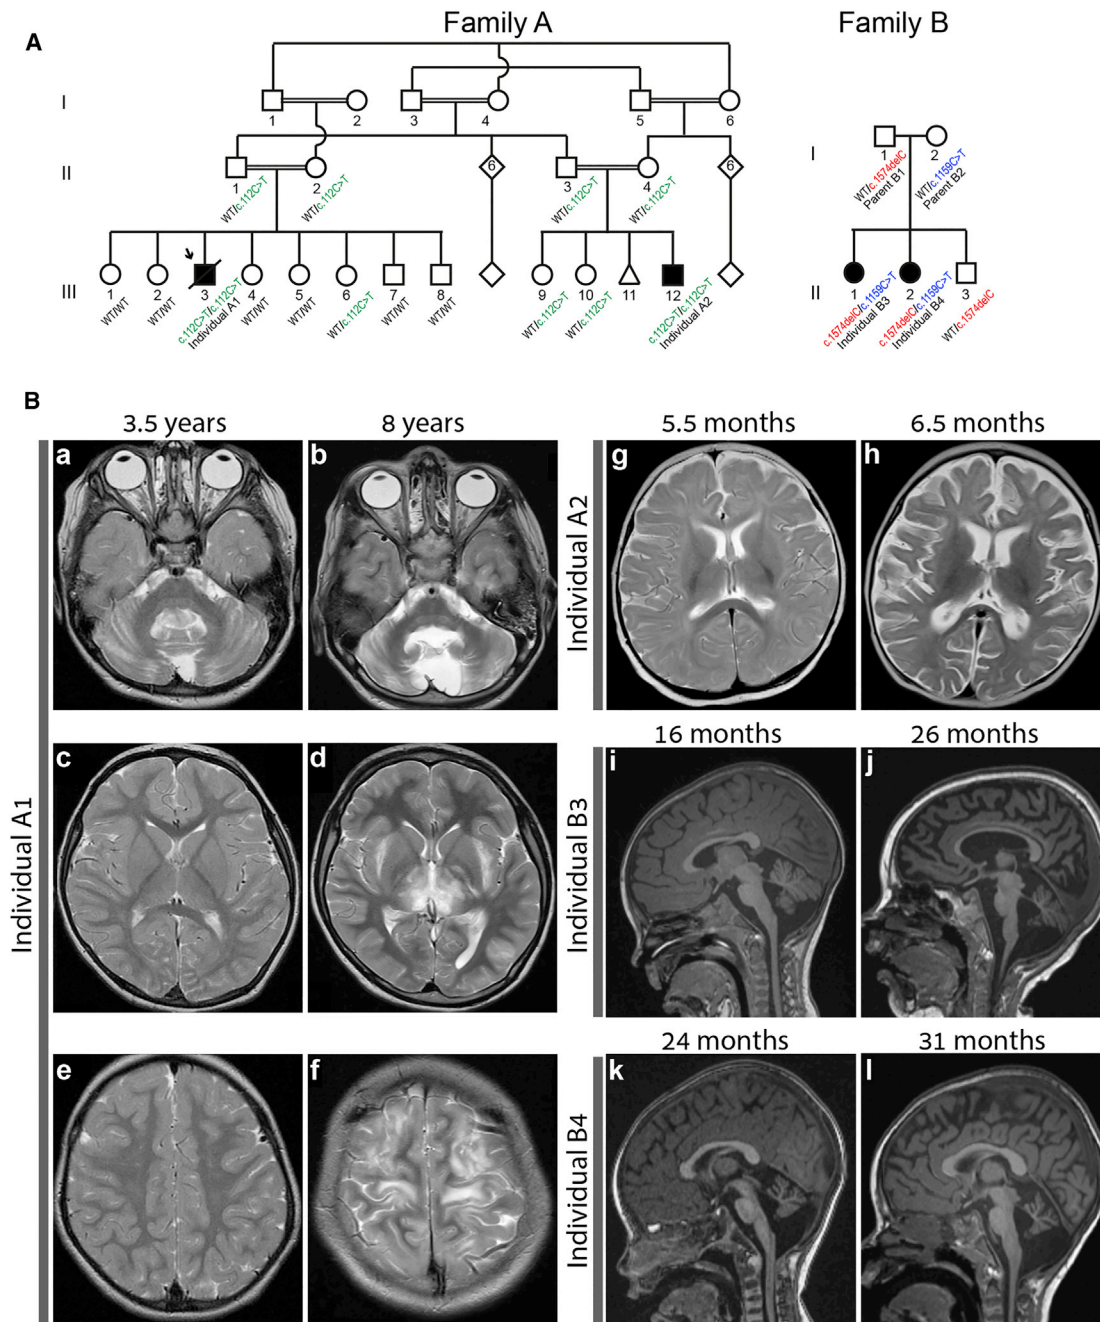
Genetic Segregation of the *NUP214* Variants and Brain Magnetic Resonance Imaging (MRI) of the Affected Individuals
